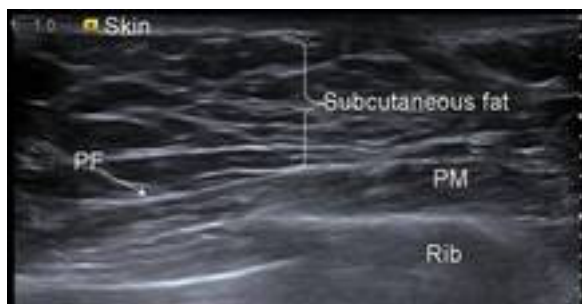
Male Breast Ultrasound
